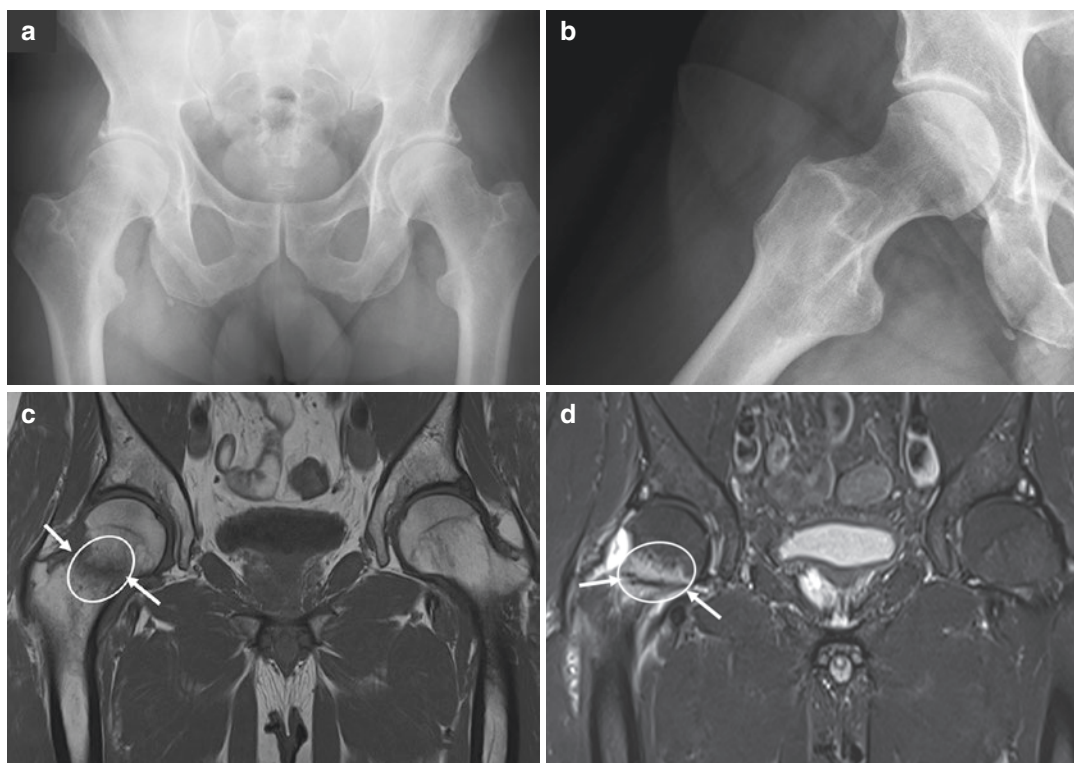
(a) AP pelvic- and (b) modified Dunn views of a 48-year-old man with recurrent groin pain 4 weeks after arthroscopic offset correction for correction of a cam deformity without a history of trauma. (a, b) Plain radiographs show no apparent fractures. (c) Coronal T1-w TSE
